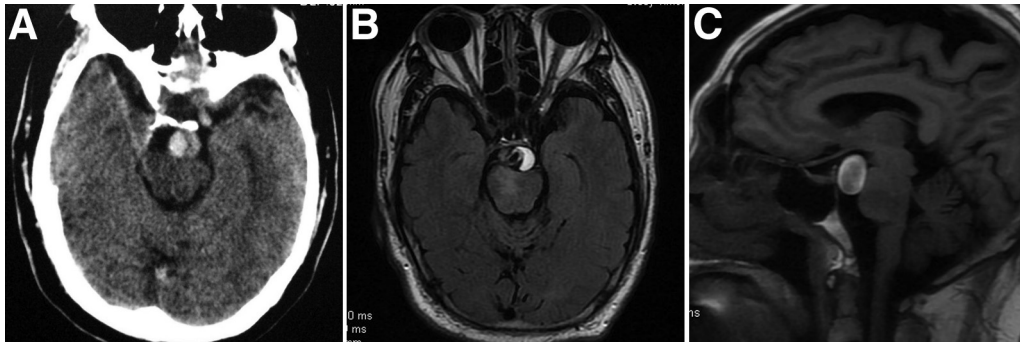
(A) Noncontrast computed tomography showed a high-density lesion in the prepontine cistern, without significant subarachnoid spreading. (B and C) Magnetic resonance imaging demonstrated an intimal flap with the double-lumen sign and a crescent-shaped thrombus within the false lumen compressing the brain stem, as well as a right pontine infarct.
